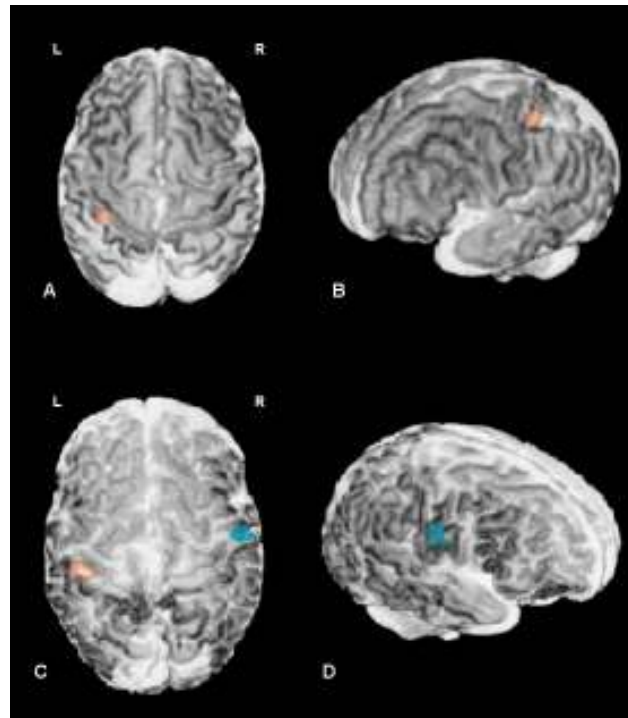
3D-rendered T2-weighted MR images of the same preterm infant studied at 34+2 weeks PMA and at term equivalent PMA. A striking increase in the folding of the cortical surface can be seen to have occurred over just 6 weeks of ex-uterine life. In the preterm period (images A,B), a single cluster of positive BOLD response (red) can be seen in the left somatosensory cortex. At term equivalent PMA (images C,D), in addition to this cluster in the left hemisphere, an area of negative BOLD response (blue) was also seen inferiorly and anteriorly in the ipsilateral hemisphere. (*note: as images have been rendered in 3D, they are not shown orientated in the radiological convention*).
